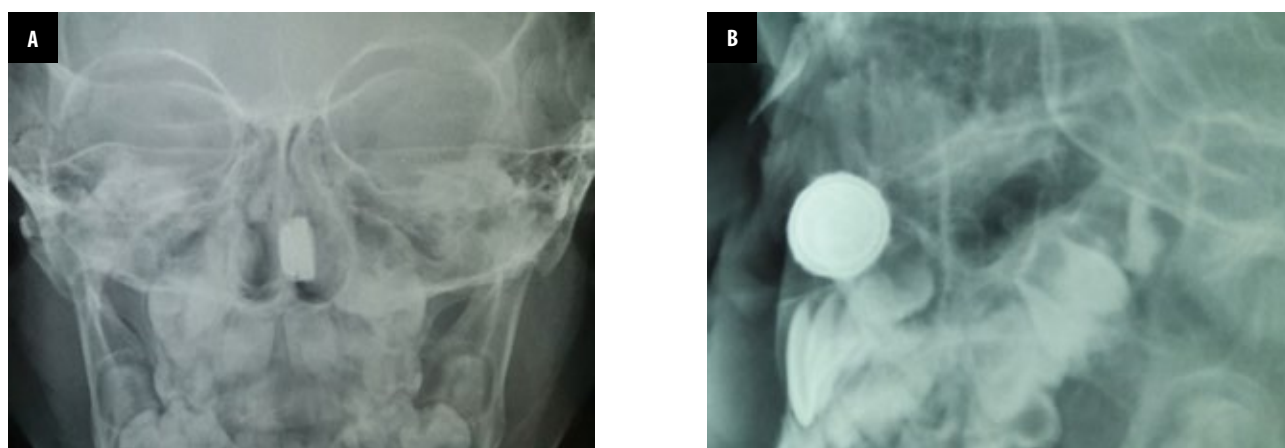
A. Plain nasal radiograph showed a step-off on anteroposterior view; B. Lateral view of plain nasal radiograph showed "double-ring" or "halo" effect
